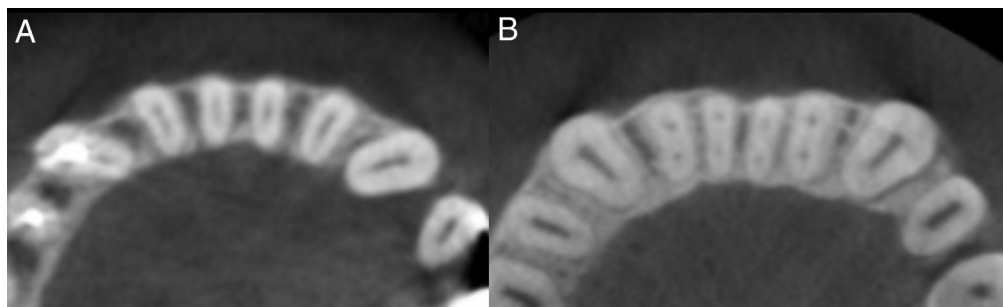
Cone-beam computed tomography images of central and lateral mandibular incisors: (A) long oval root canal and (B) 2 root canals.
